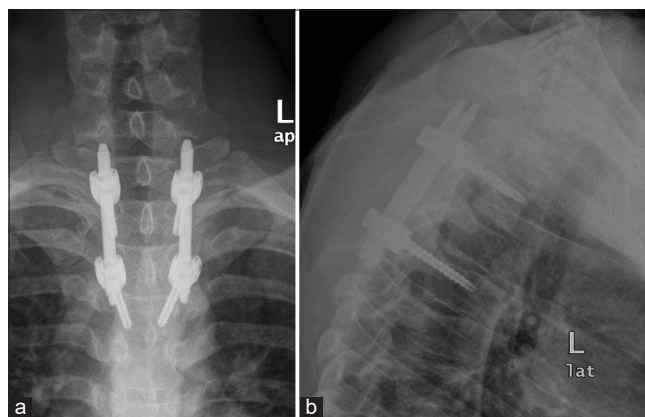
Post-operative radiographs of the thoracic spine showing posterior pedicle screw fixation in the AP (a) and lateral (b) positions.
